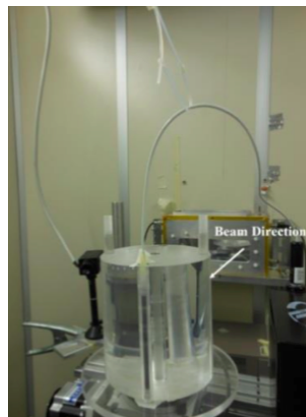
Computed Tomography Dose Index (CTDI) experimental set up: the synchrotron radiation beam comes from the right part and impinges on the PMMA phatom in which the RADCAL chamber was insert.
